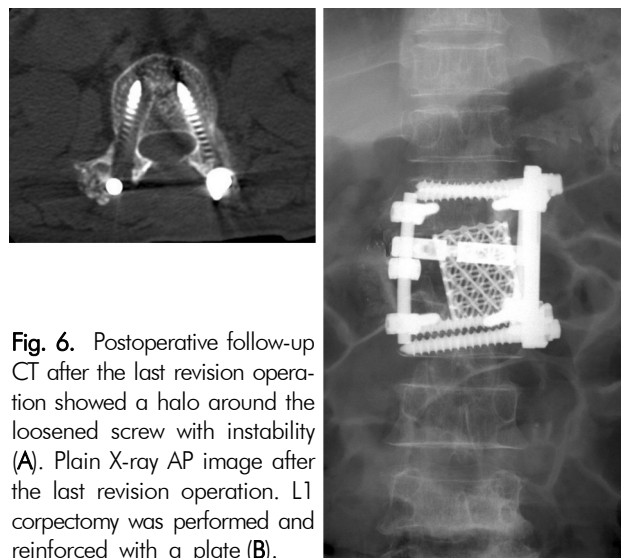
Postoperative follow-up CT after the last revision operation showed a halo around the loosened screw with instability (A). Plain X-ray AP image after the last revision operation. L1 corpectomy was performed and reinforced with a plate (B).
